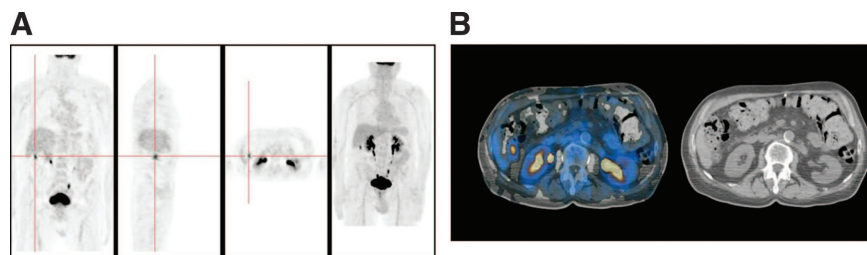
An 81-y-old man with cancer of sigmoid colon, after surgery, increasing carcinoembryonic antigen (CEA) serum levels, and a repeated negative CT study. (A) PET shows focal area of increased ^{18}F -FDG uptake in right upper abdomen. (B) Hybrid PET/CT images precisely localized this uptake to colon, consistent with physiologic bowel excretion. Malignancy was excluded and study was reported as normal. Patient had no evidence of recurrence in colon during 15 mo of clinical follow-up.
